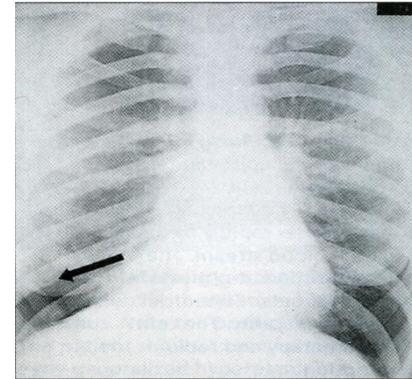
Right-sided pneumothorax in an adult woman with asthma. The edge of the collapsed lung is not so obvious as in Fig.17, and it is important to consider pneumothorax whenever examining the chest X-ray of a patient with an acute respiratory problem. The edge of the collapsed lung is marked with an arrow.
